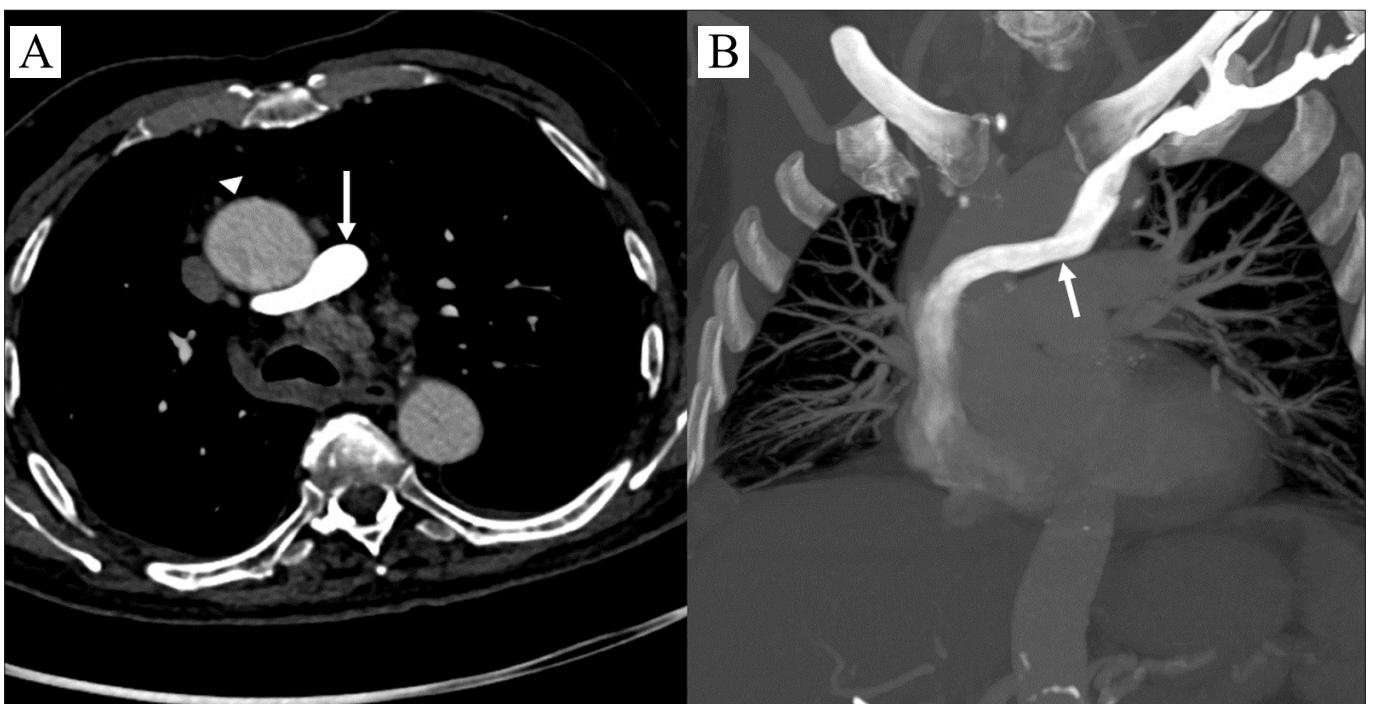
Post-contrast axial CT (a) and coronal MIP (b) images show contrast agent administration from the left arm. It shows that the left brachiocephalic vein (arrow) passes from the posterior of the ascending aorta (arrowhead) to the right half of the mediastinum.
